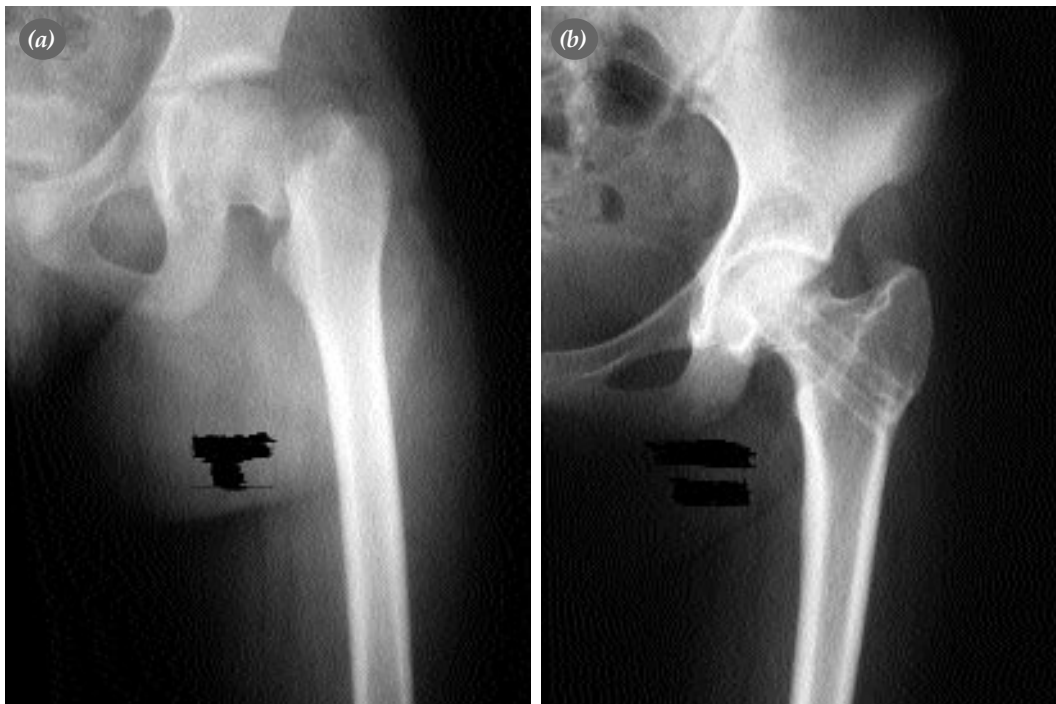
(a) AP radiograph of a 11 year old girl with transcervical femoral neck fracture. (b) Eleven days after the trauma closed reduction and internal fixation was performed with two screws. AP radiograph at 59-months follow-up shows coxa vara deformation. The result was classified as 'good' according to Ratliff's criteria.
